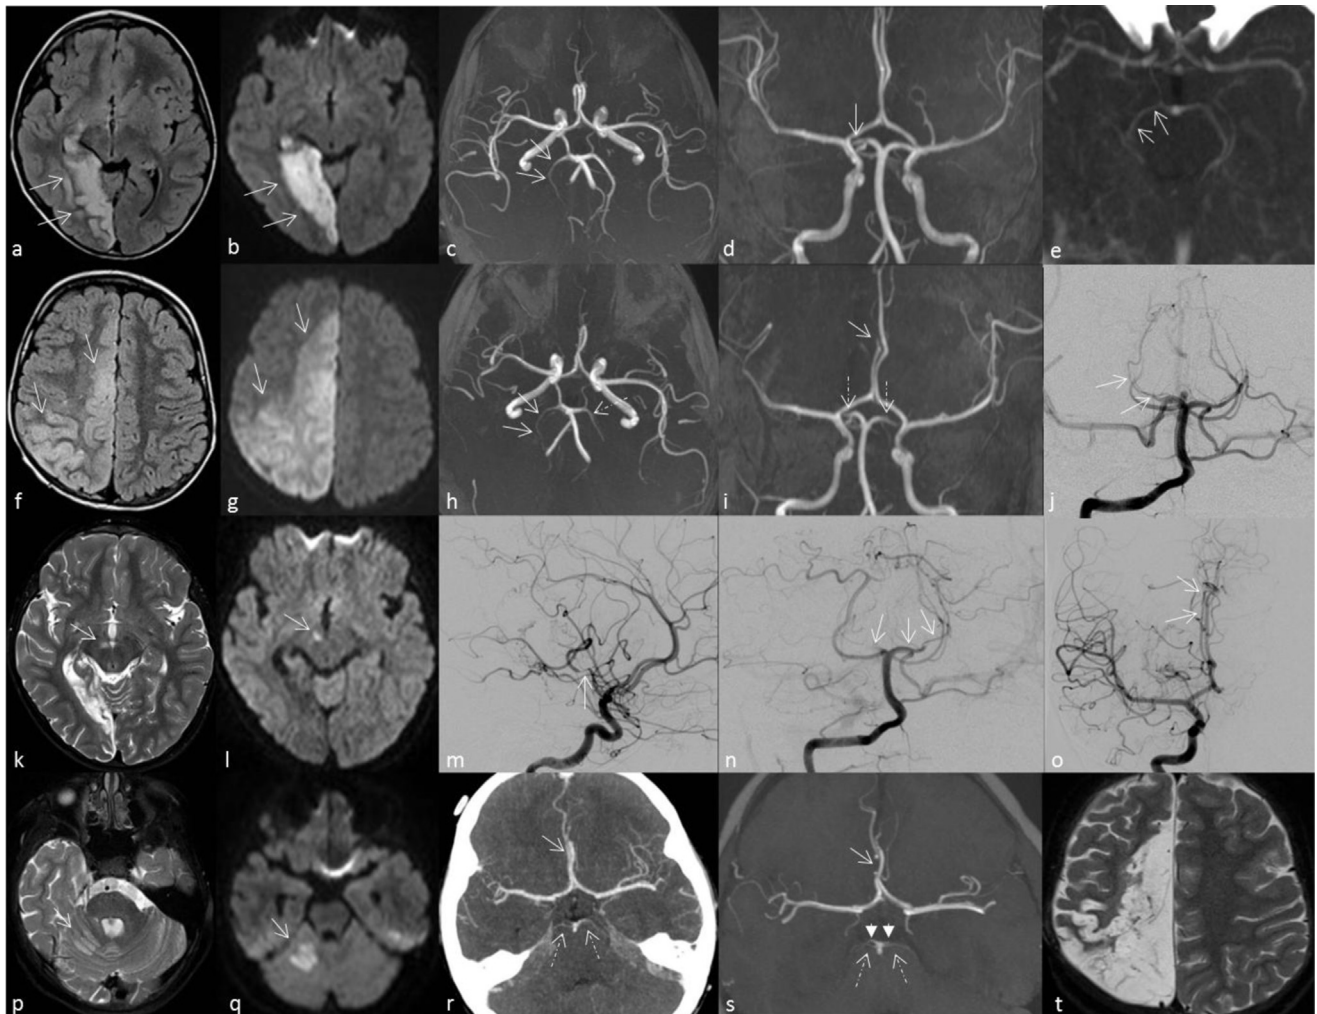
Overview of images after the consecutive strokes: a-e: episode 1: a-b. MRI: axial fluid attenuated inversion recovery (FLAIR) and axial diffusion weighted imaging (DWI) (arrows: infarction in right PCA territory), c-d. axial and coronal reconstruction of MRA time-of-flight (TOF) (arrows: narrowing of right PCA), e. maximum intensity projection (MIP)-image of CT angiography (arrows: narrowed right PCA as compared to left PCA) f-j: episode 2: f-g. MRI: axial FLAIR and DWI (arrows: extensive ischemic area in right ACA territory), h-i. axial (arrows: very thin aspect of right PCA, dotted arrow: narrow aspect of left PCA) and coronal (arrow: ‘stop’ image of right ACA, dotted arrows: thin aspect of both PCAs) reconstruction of MRA TOF, j. cerebral angiography (arrows: very thin aspect of right PCA) k-o: episode 3: k-l. MRI: axial T2 and DWI (arrows: ischemic area involving right cerebral peduncle), m-o. cerebral angiography (m. arrow: stenosis of posteroparietal branch of MCA, n. arrows: ‘stop’ image of right PCA and very thin aspect of left PCA, o. arrows: narrowed right ACA with ‘stop’ image and collateralization) p-t: episode 5: p-q. MRI: axial T2 and DWI (arrows: ischemic lesion in the superior cerebellar artery territory), r. MIP-image of CT angiography (arrow: thin aspect of right ACA, dotted arrows: thin aspect of both PCAs), s. semiaxial reconstruction of MRA TOF (arrow: thin aspect of right ACA, dotted arrows: thin aspect of both superior cerebellar arteries, arrowheads: ‘stop’ images of both PCAs), t. MRI T2 (end stage image with extensive encephalomalacia in the right ACA territory).
